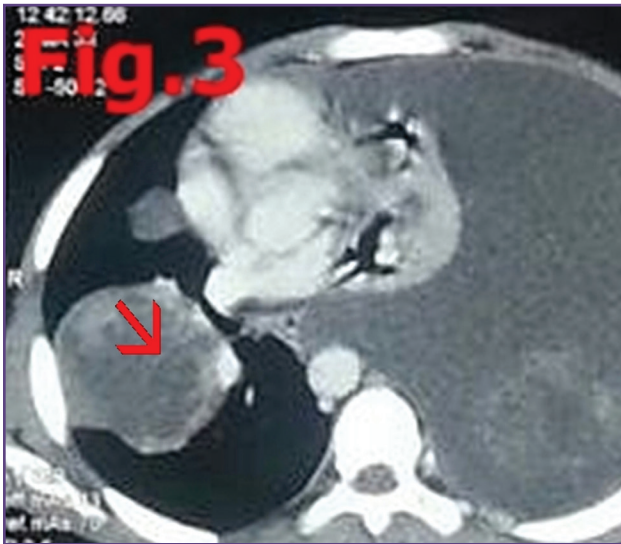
CT scan showing massive left sided pleural effusion with shift of mediastinum to contralateral side with basal pleural thickening and floating lily sign (yellow arrow) and round well circumscribed fluid filled cystic lesion with multiple septations (red arrow) suggestive of multiple daughter cysts and basal hydatid sand on the right side.
